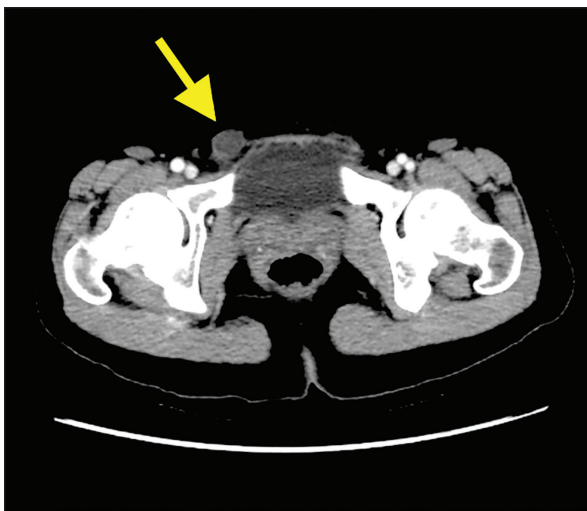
Axial contrast enhanced abdominal CT scan. A right inguinal cystic and solid mass (yellow arrow).
